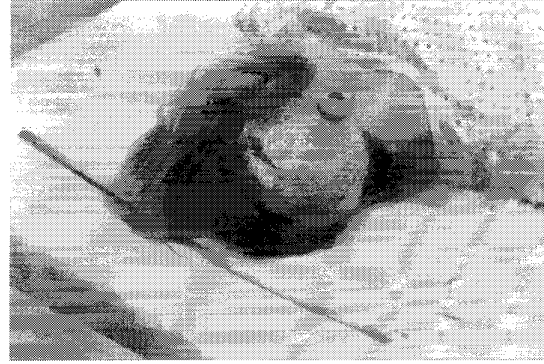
Examples of combining the registration of MRI to laser data and the calibration of a video camera relative to the laser to provide an enhanced reality visualization of patients. In each case, the tumor and the ventricles are displayed in registration with the patient.
